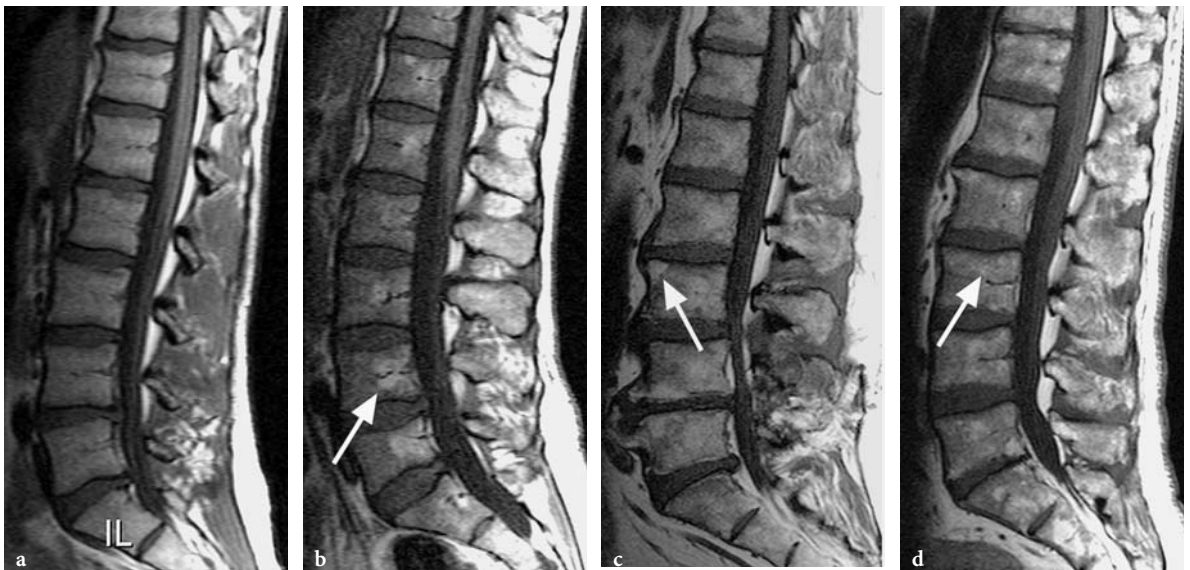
Sagittal T1-weighted SE images in a 28-year-old (a), a 41-year-old (b), a 50-year-old (c) and a 74-year-old (d) volunteer. A rather low bone marrow signal is seen in the younger volunteer, except for a linear area of high signal superior and inferior to the basivertebral vein (b, *arrow*). With increasing age, areas of linear or triangular hyperintensity become visible near the end plates and at the corners of the vertebral body (c, *arrow*). In addition, focal areas, ranging in size from 0.5 to 1.5 cm, and/or small dots measuring a few millimeters can be seen (d, *arrow*)
